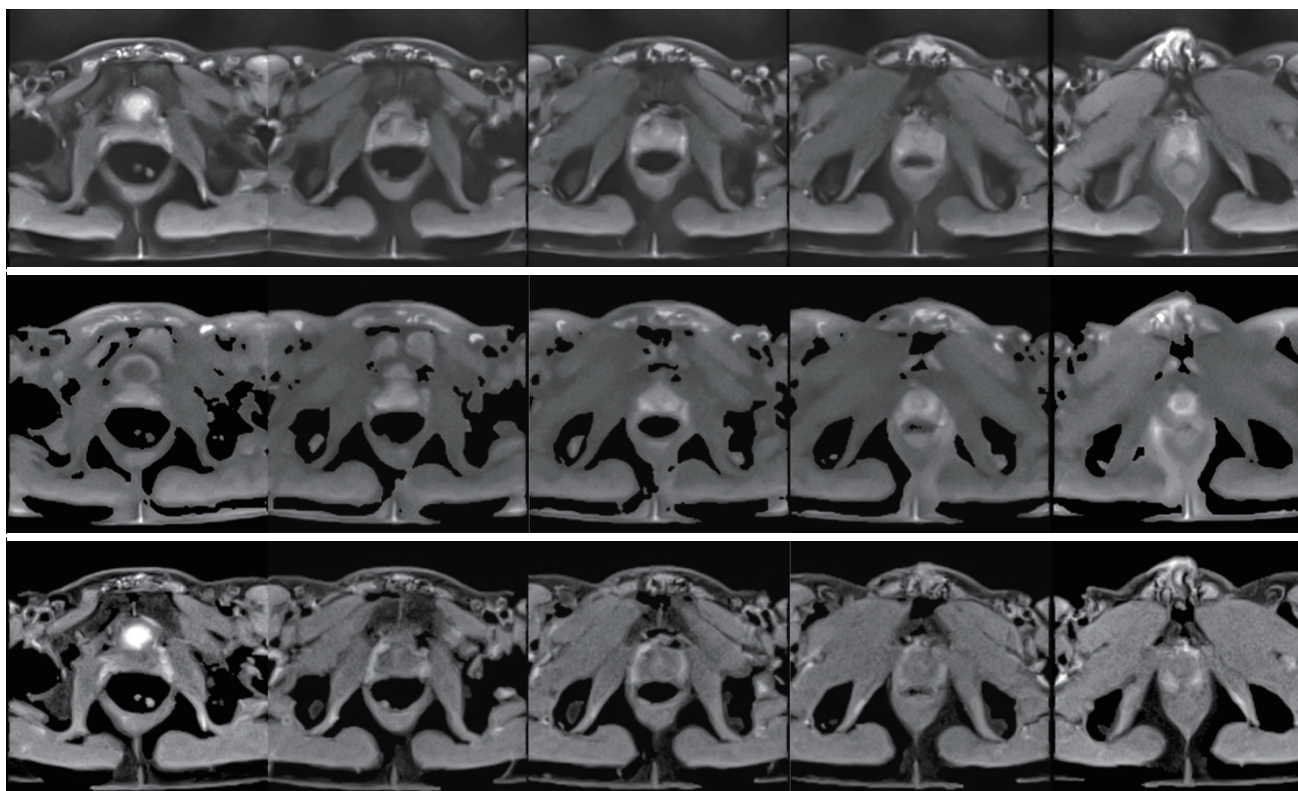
(Top row) non-diffusion-weighted (non-DW) images ($b = 0$), (middle) mean DW images ($b = 600 \text{ s/mm}^2$, 6 gradient directions) and (bottom) apparent diffusion coefficient (ADC) maps of the prostate of a healthy volunteer as obtained by DW single-shot stimulated echo acquisition mode (STEAM) MRI. The 5 slices (left to right, every other section) are selected from a series of 31 directly neighboring cross-sections at 3-mm thickness. The total measuring time was 4 min 30 s. For other details see *Table 1*.
